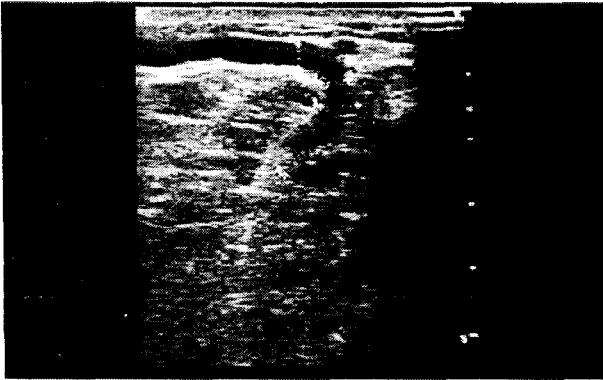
Ultrasonic dopplerography of Perforate Vein (PV)
